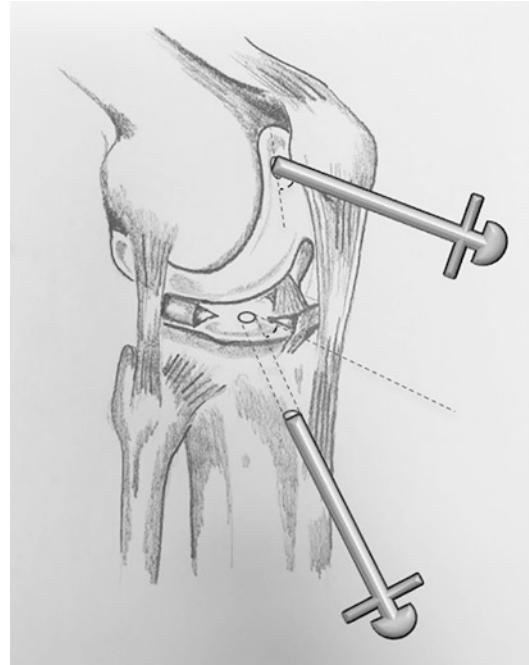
Tibial osteochondral autograft transplantation. A steep tunnel is drilled through the tibia exiting at the defect site. The articular entry angle between the drill tunnel and the tibia plateau is determined (visually or via X-ray), and the graft is harvested with the trephine entering the harvest site at the exact same angle. This ensures flush cartilage integration after retrograde graft insertion
